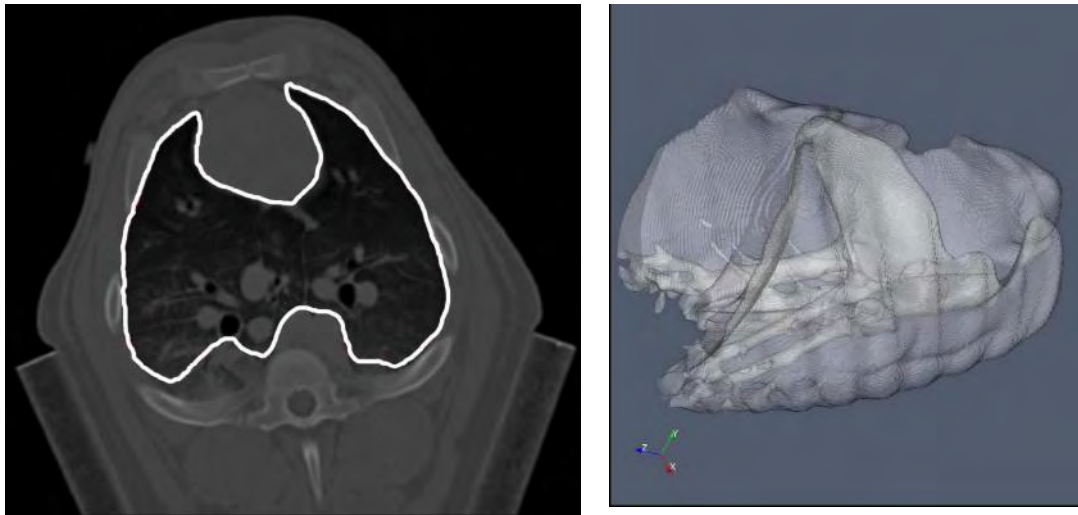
Segmentation of lung region from CT data set (left side) and volume rendering of segmented region (right side)
